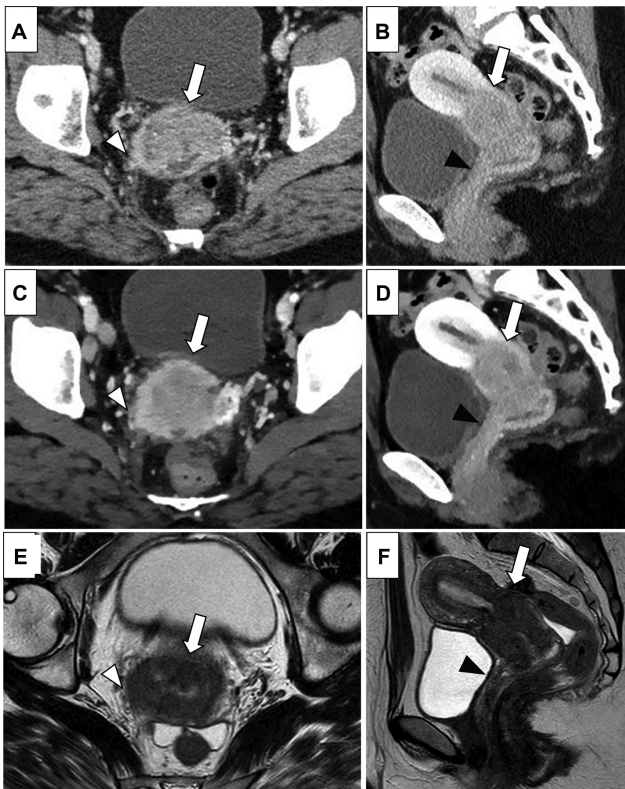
A 38-year-old female patient with cervical cancer (squamous cell carcinoma), clinically diagnosed with International Federation of Gynecology and Obstetrics (FIGO) 2018 IIIB. (A, B) Conventional computed tomography (C-CT) axial, sagittal images. (C, D) Virtual monoenergetic image (VMI) axial, sagittal images. (E, F) T2-weighted image (T2WI) axial, sagittal images. The tumor shows relative hypoattenuation with strongly enhanced margins (A–D; arrows), predominantly reaching the right pelvic wall (A, C; arrowheads) and invading the upper two-third vaginal wall (B, D; black arrowheads) on CT. T2WI showing spiculated tumor-to-parametrial interface reaching the iliac vasculature (E; arrowhead), and thickening of the anterior vaginal wall (F; black arrowhead). On C-CT, only one reader misdiagnosed as no parametrial invasion, and all the readers correctly diagnosed vaginal invasion. On VMI, half of the readers overdiagnosed with bladder and rectal involvement, as well as the lower one-third vaginal involvement. On magnetic resonance imaging (MRI), all readers correctly diagnosed lateral invasion, but only one reader correctly diagnosed vaginal invasion.
